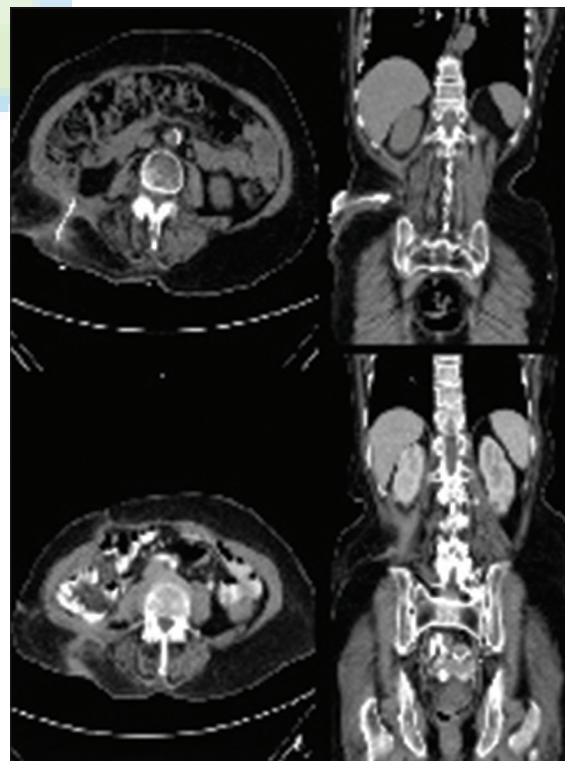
Computed tomography before secondary fibrin glue injection and after secondary fibrin glue injection with near-total resorption of the fistula tract
